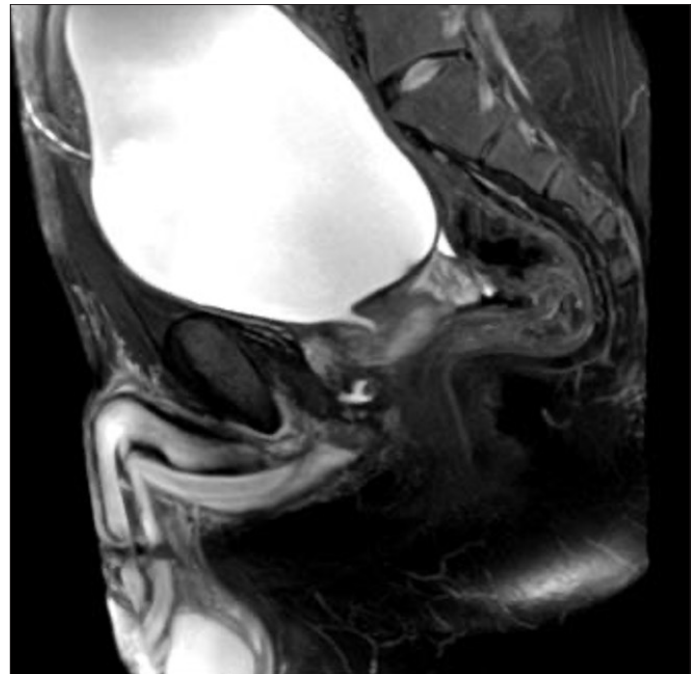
Magnetic resonance imaging (MRI) showing high-lying prostate with posterior dislocation
